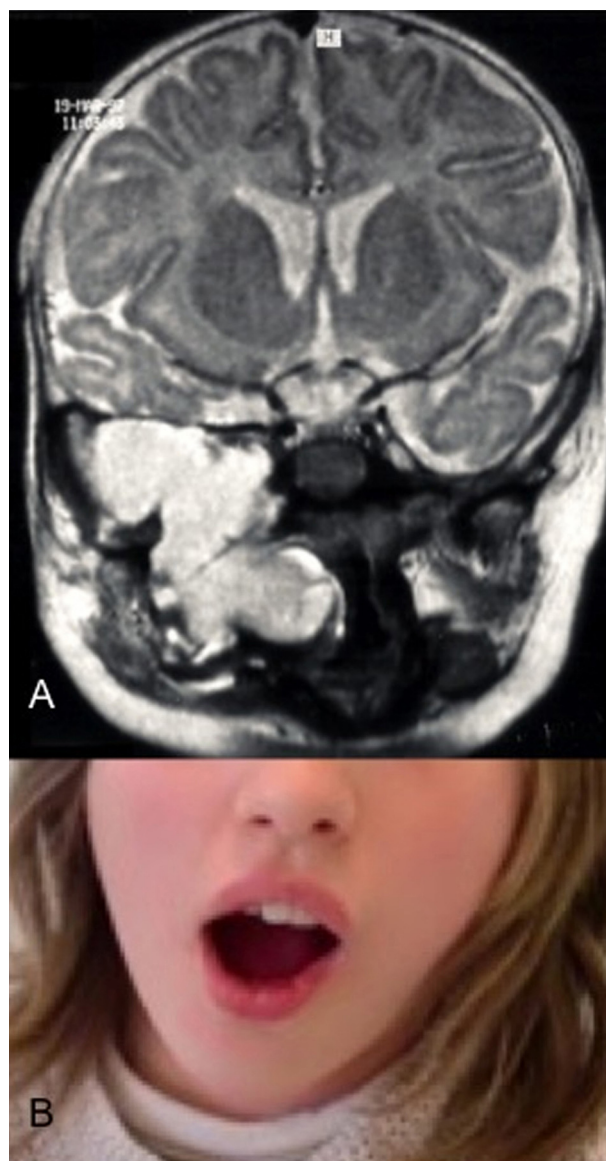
A. MRI, T2-weighted sequence in a neonate (case 2). The oropharyngeal teratoma has a heterogeneous, polycystic appearance, invading the right infratemporal fossa with intracranial and extrameningeal extension. B. Clinical appearance (case 2) of the child at the age of 14 years with right lateral mandibular deviation and limited mouth opening.
